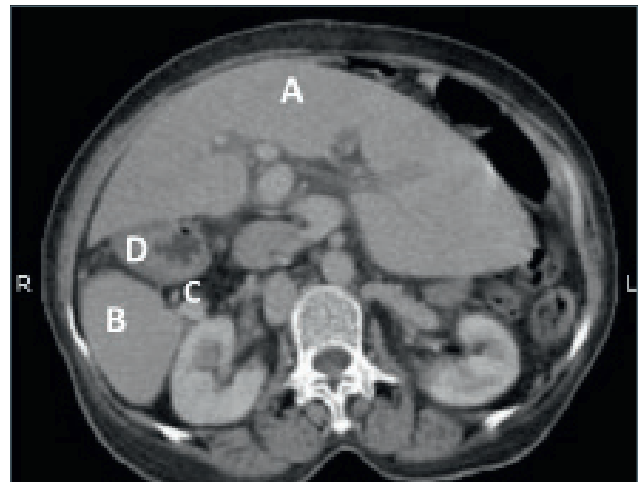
HRCT thorax with abdomen showing:
